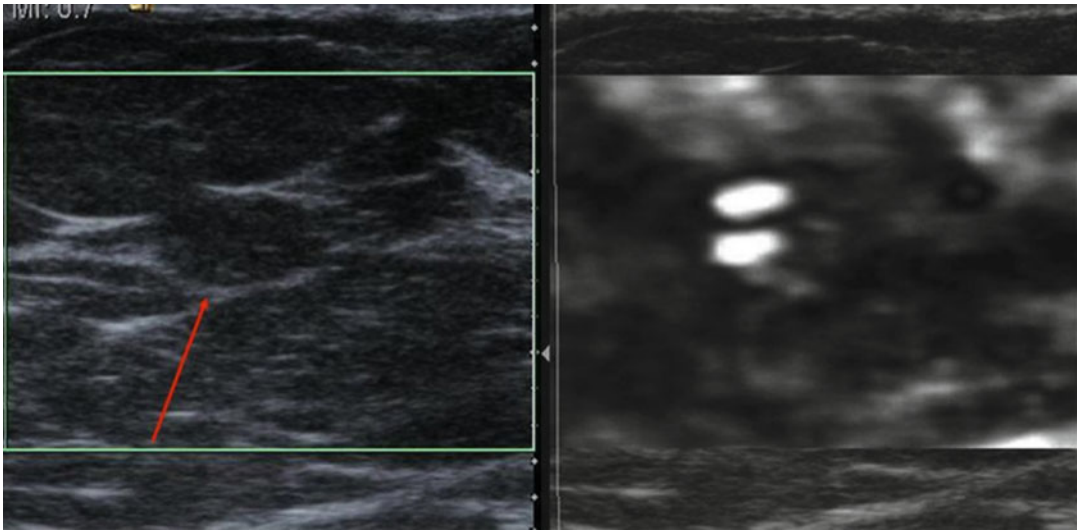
Ultrasound images from a 39-year-old female with a palpable mass and a negative ultrasound examination and mammogram at a different institution. An elastogram taking at the site of the palpable abnormality
